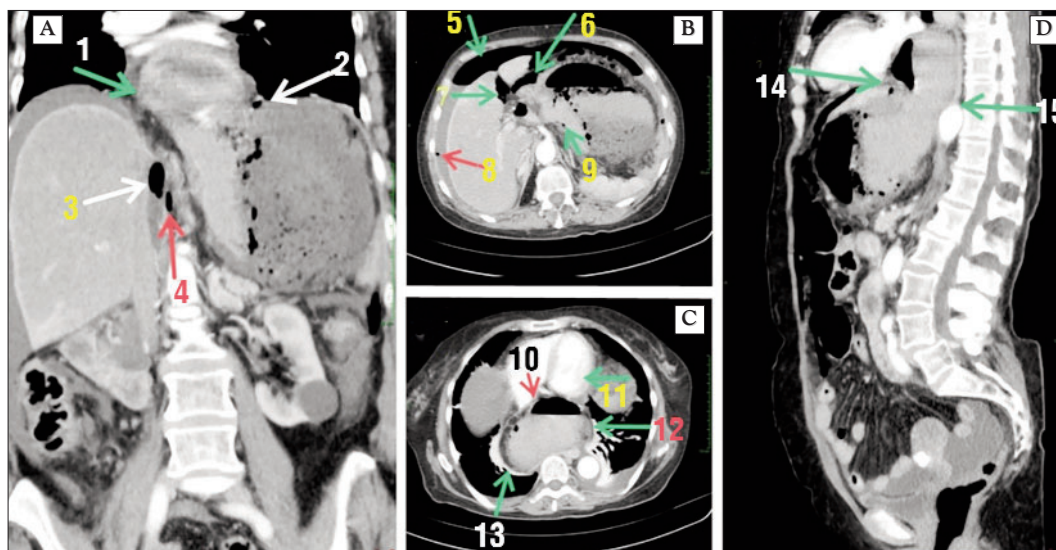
Contrast-enhanced computed tomography of incarcerated hiatal hernia: (A) Frontal view showing intra-abdominal free air and fluid; (B, D) Axial and sagittal views depicting the intrathoracic stomach; (C) Axial view showing abdominal fluid.
